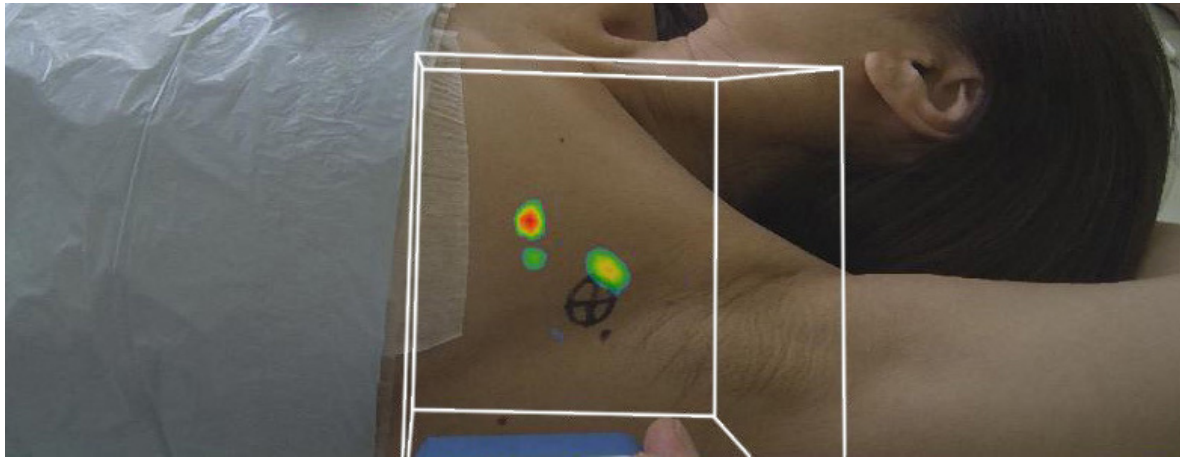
Augmented reality view of a fhSPECT reconstruction of radio-marked lymph nodes in the axilla of a breast cancer patient. (*Courtesy of Philipp Matthies.*)
